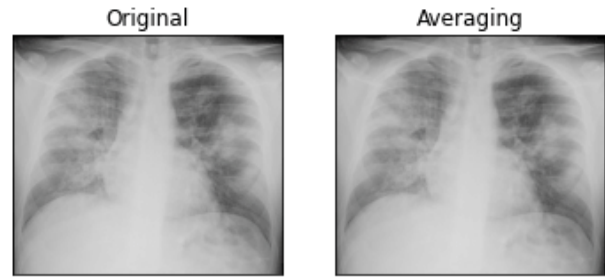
(c). Outputs of first X-Ray image before and after filtering it using Mean Filter
